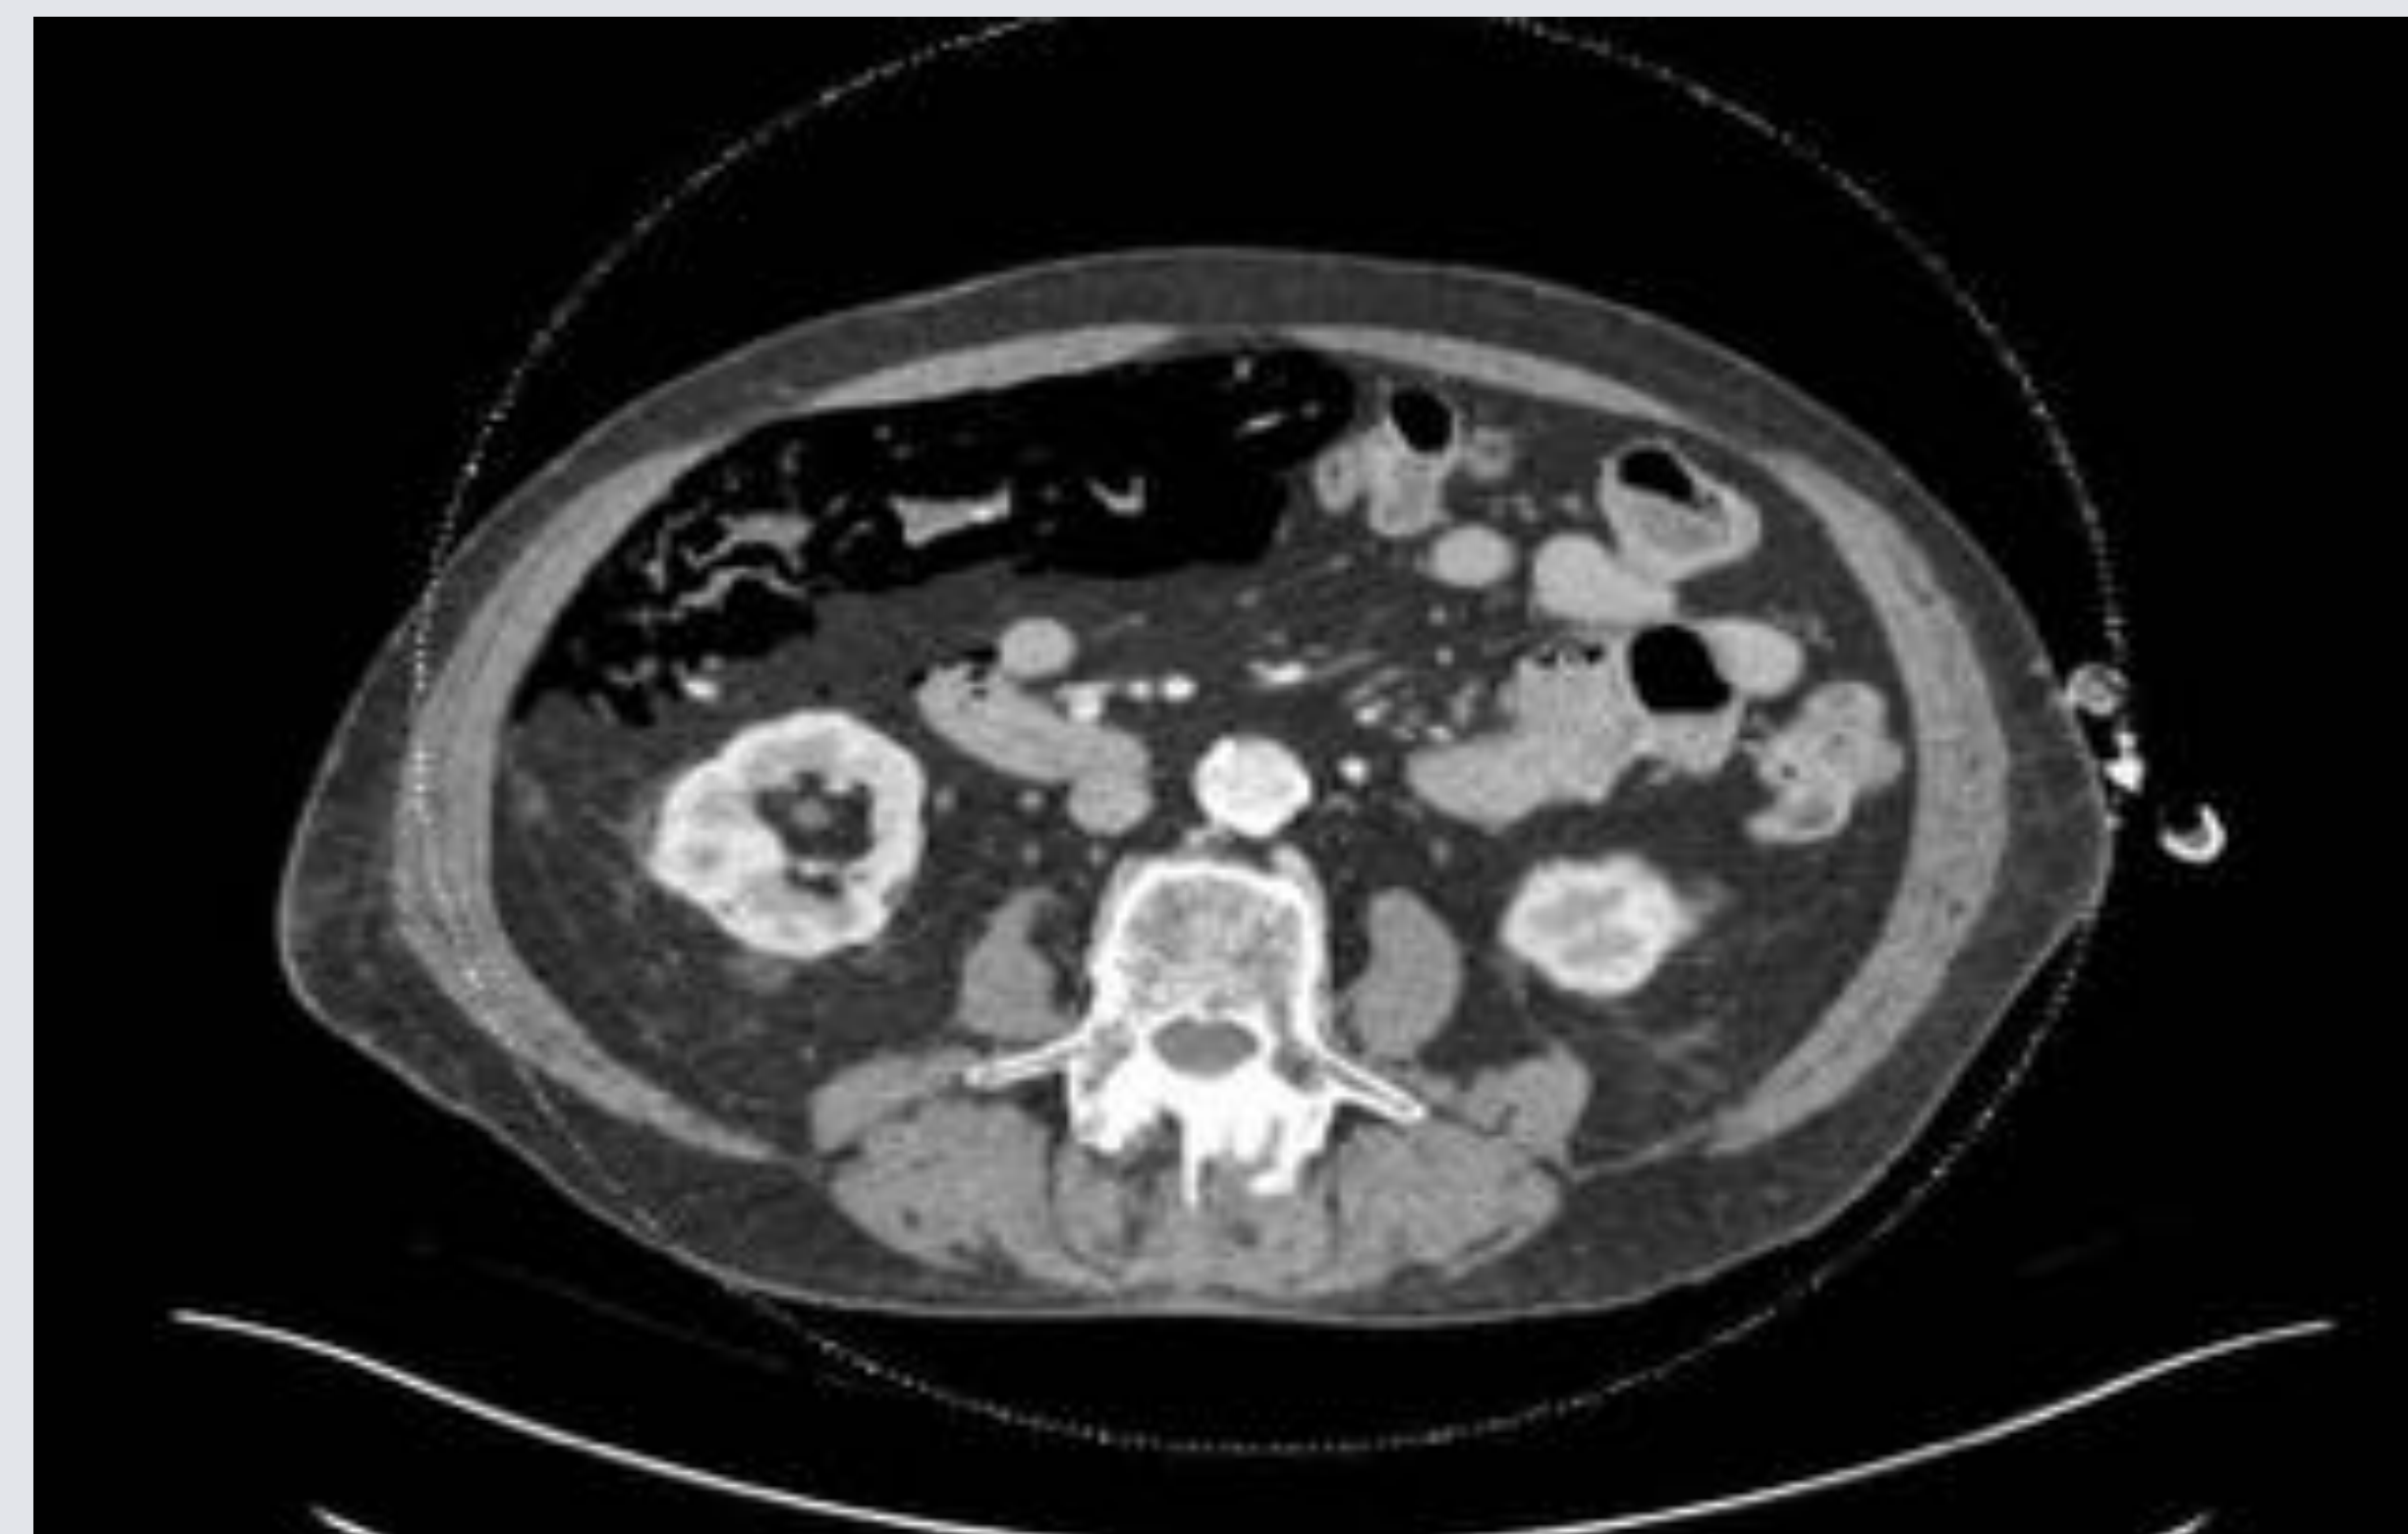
CT scan showing pneumoperitoneum and pneumatosis of ascending colon
